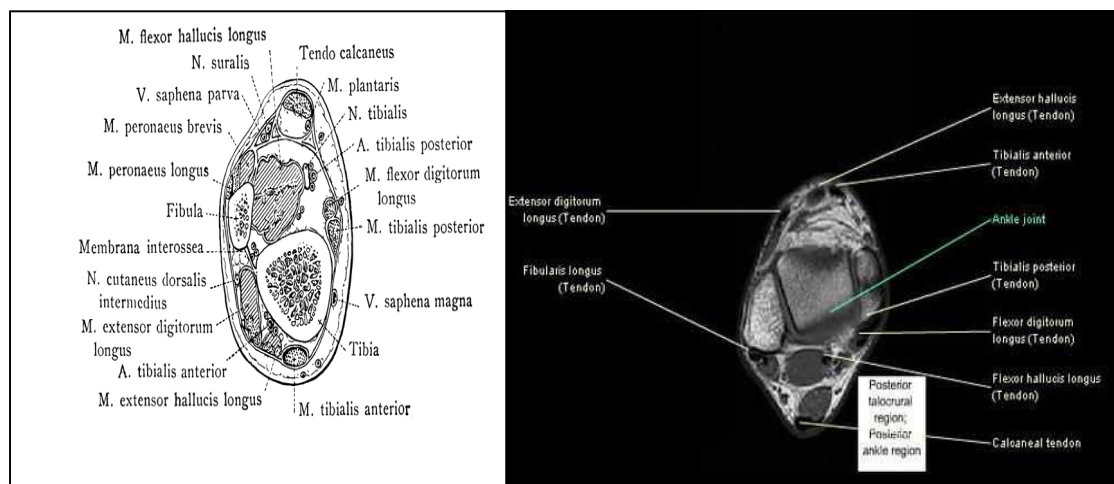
Transverse section and MRI through ankle (9).
